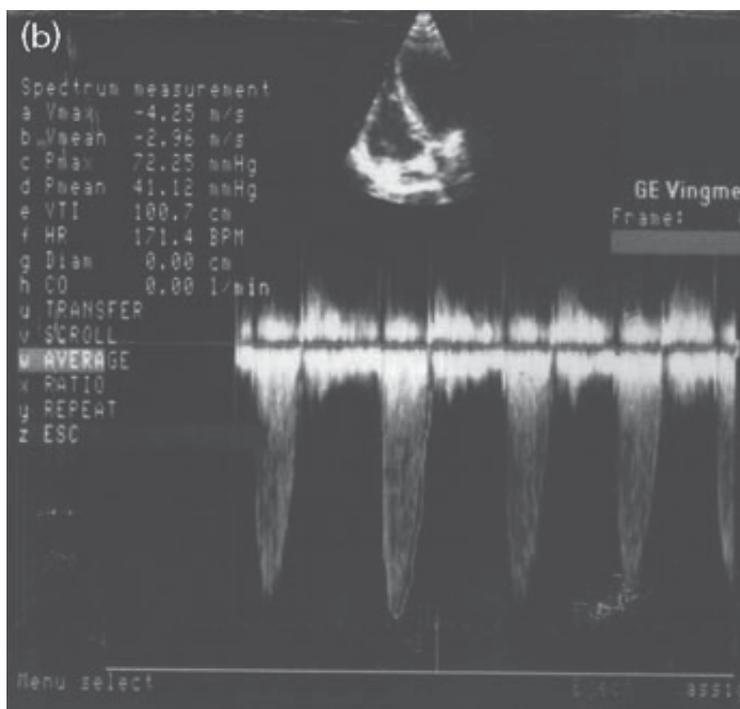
Continuous wave Doppler recording of a bicuspid aortic valve (from apical five-chamber approach) showing severe stenosis across the valve and mild regurgitation
